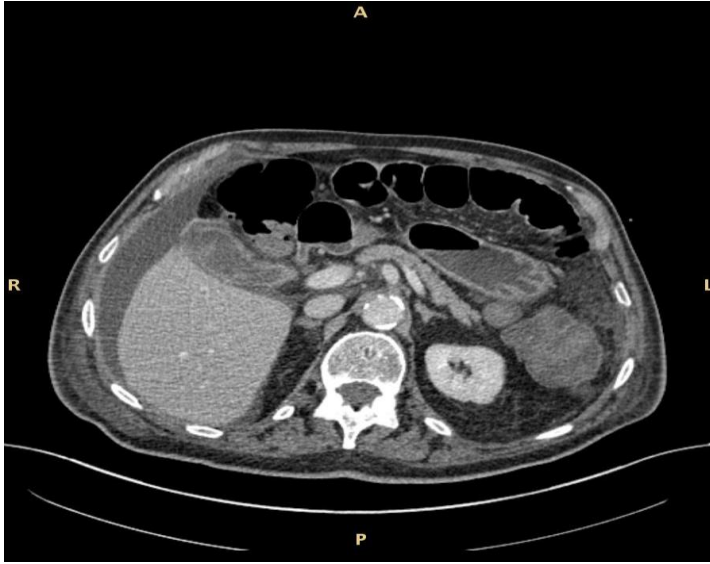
The abdominal CT-scan that revealed an empyema of the gallbladder, with bilious effusion in the abdominal cavity.
